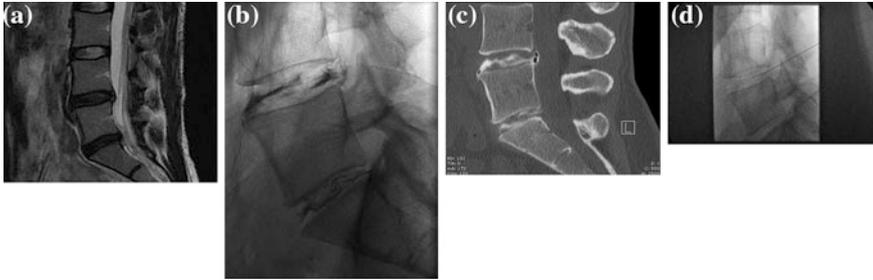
Case #1 a L4-5 and L5-S1 disc degeneration, T2 MRI. b Discogram showing spread of contrast outside the nucleus pulposus of L4-5 and L5-S1, consistent with annulus fibrosus tears. c Post-discogram CT scan showing annulus fibrosus tears at L4-5 and L5-S1 and vacuum disc at L4-5. d Needles in position for PRP injection
